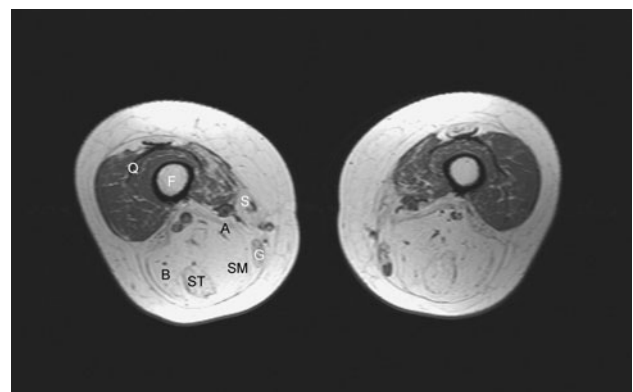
MRI scan T1 weighted of upper leg muscles showing severe fatty degeneration of posterior muscles differing from anterior muscle compartment (pat. 6). *F* femur, *A* adductor muscles, *B* biceps femoris muscle, *G* gracilis muscle, *SM* semimembranosus muscle, *ST* semitendinosus muscle, *S* sartorius muscle
